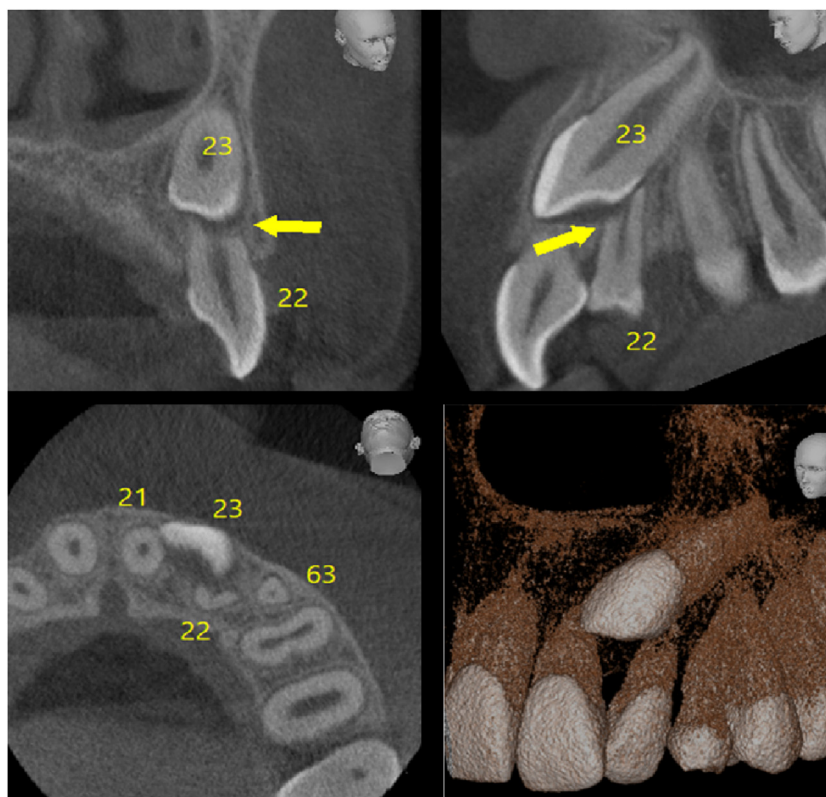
The cone beam computed tomography image of the same case seen in Figure 1, depicting slices from the coronal, sagittal, and axial planes. After additional cone beam computed tomography information, the therapy for this case changed from surgical exposure and extrusion of tooth 23 without any permanent tooth extractions to extraction of tooth 22 in addition to extrusion. Tooth 23 is located buccal to tooth 22. The lateral incisor's resorption is deep.
